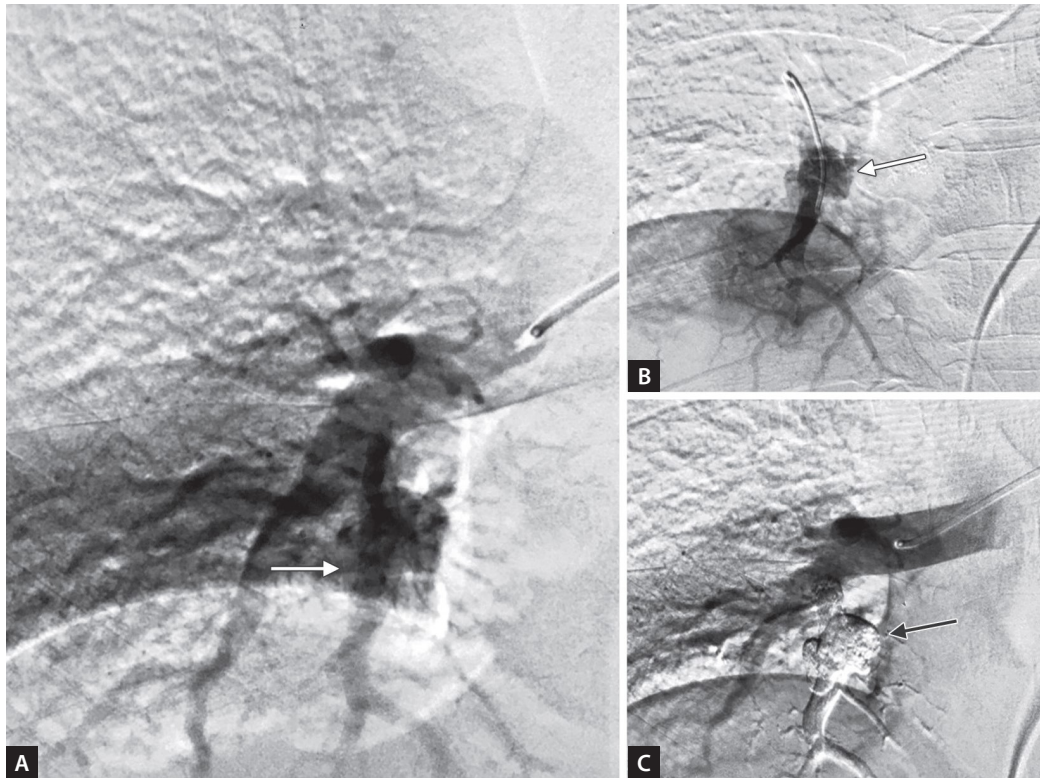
to C: Patient with massive hemoptysis. History of COVID and admission for the same before 1 month. (A) CT pulmonary angiography image showing aneurysm (white arrow) with surrounding consolidation of posterobasal branch of the right descending pulmonary artery; (B and C) Anteroposterior and lateral views after N-butyl-cyanoacrylate (NBCA) cast formation inside the bleeder branch as well as occluded pseudoaneurysm (black arrow).
